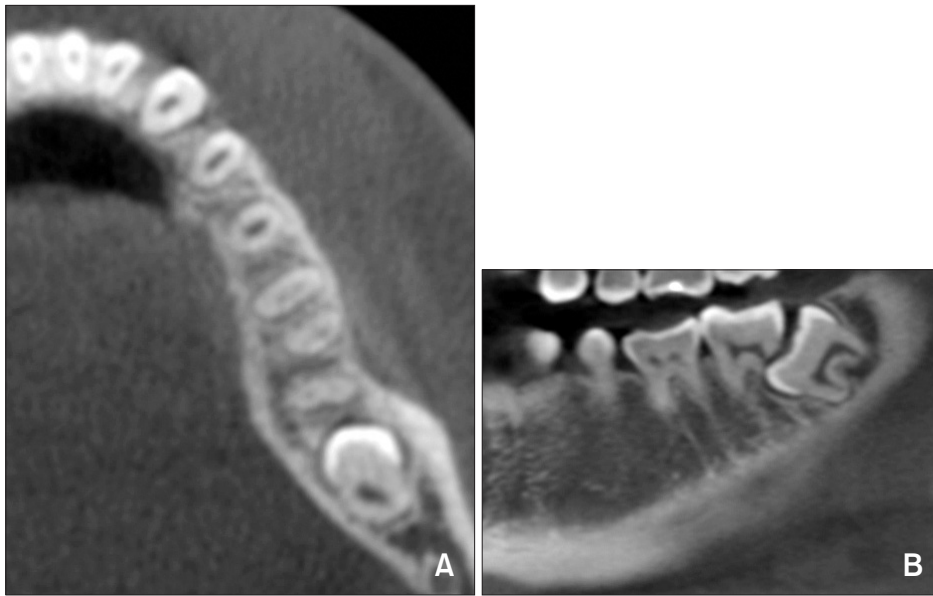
Computed tomography images showing that more than half of the distal root of tooth #37 was affected by tooth #38 (A: axial view, B: sagittal view).
